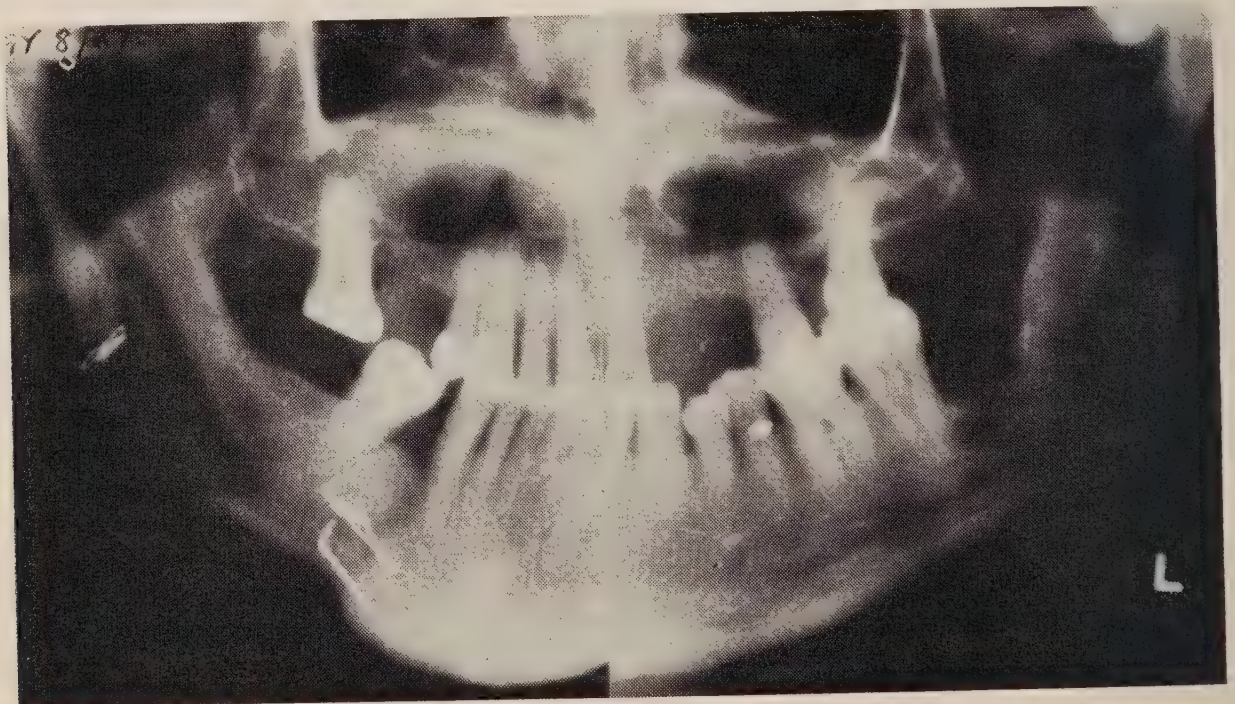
Panoramic radiograph showing postoperative results after one year.
